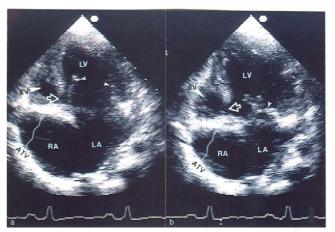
Apical four chamber two-dimensional echocardiographic views of a child with tricuspid atresia showing an enlarged left ventricle (LV), a small right ventricle (RV) and a dense band of echoes, representing atretic tricuspid valve (ATV) at the site where the tricuspid valve echo should be. Atrial (not labeled) and ventricular (open arrow-head) septal defects are also seen. Note the attachment of the detectable atrioventricular valve to the left side of the interatrial septum. Frames a and b show open and closed mitral valve leaflets (closed arrow-heads) respectively. LA, left atrium; RA, right atrium.
